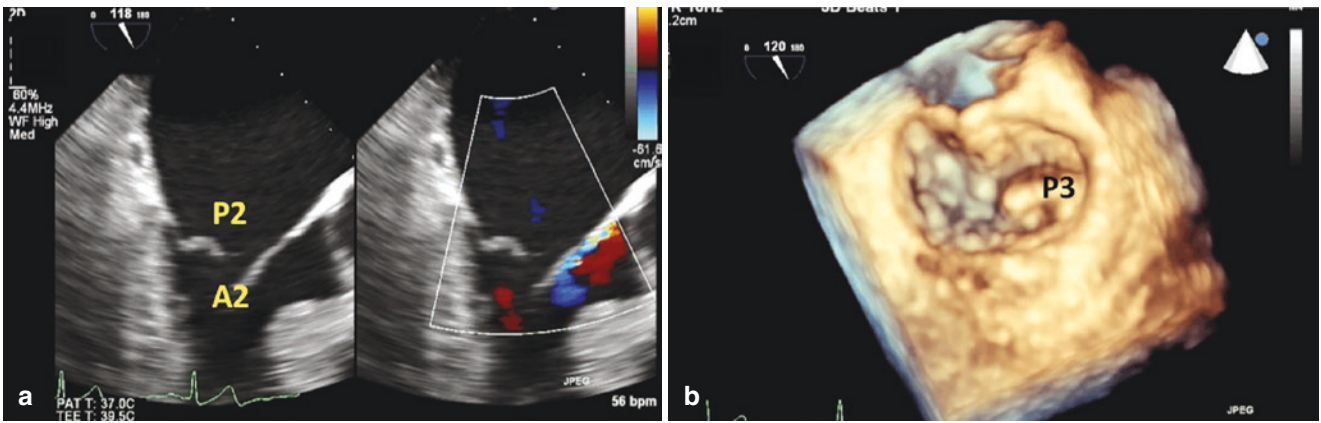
Transesophageal echocardiogram (TEE) demonstrating that 2D TEE by itself may lead to misrepresentation of scallops. In panel a at 120°, the P2 scallop appears to be flail. However in panel b when 3D
